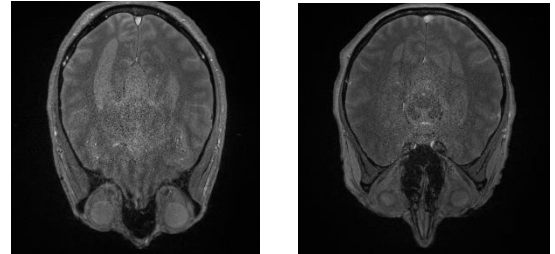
Brain MRI images of a normal Brain and a brain Parkinson's Disease
